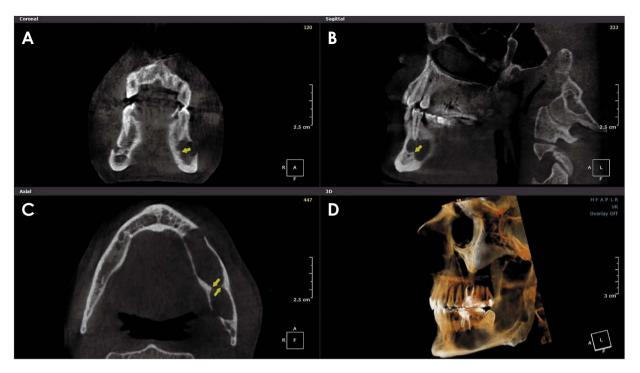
Simple bone cyst on cone-beam computed tomographic images. A. Coronal view shows a scalloped border in the medial border of the mandibular body (arrow). B. Sagittal view shows a scalloped border in the anterior border of the lesion (arrow). C. Axial view shows scalloped borders in the buccal and lingual aspects of the lesion (arrows). D. Three-dimensional surface-rendering image shows a spatial view of the lesion on the left side of the mandible.
